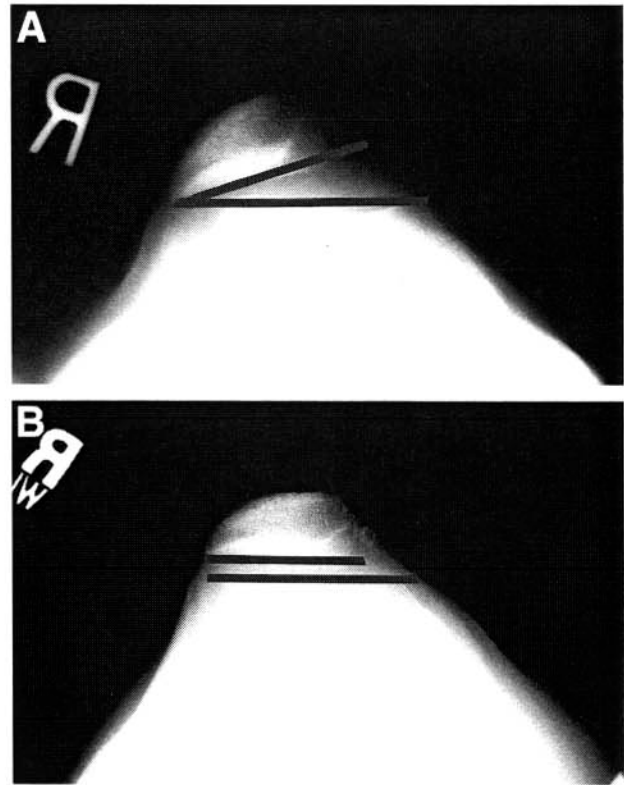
(A) Preoperative and (B) postoperative Merchant view radiographs showing improvement in lateral patellofemoral angle. The average improvement in the lateral patellofemoral angle was from -3° preoperatively to $+9.4^\circ$ postoperatively.
